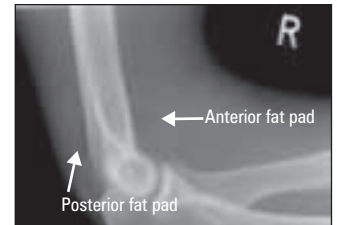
X-Ray of Fat-Pad Sign
